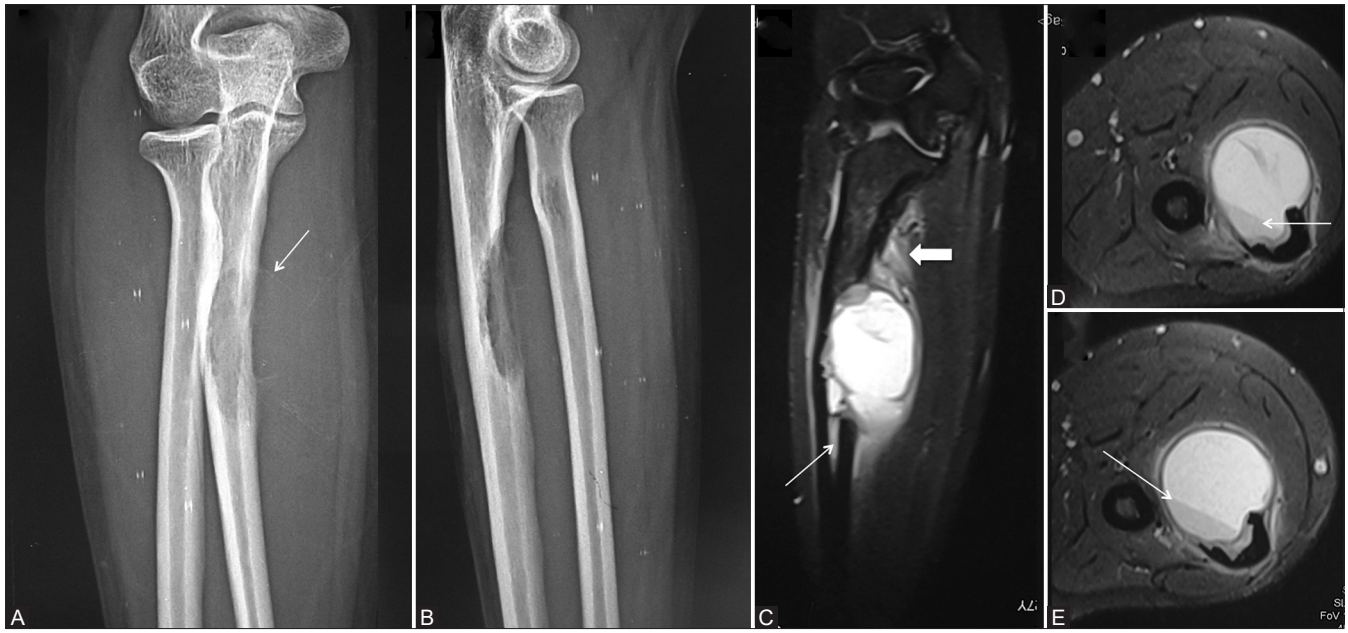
(A-E): A 27-year-old female with painless progressive swelling in the left forearm. (A and B) AP and lateral radiographs of the forearm including elbow joint showing expansile, eccentric lytic lesion with a thin shell of the cortex (arrow) arising from the proximal diaphysis of the ulna. (C-E) Coronal and axial T2W fat-saturated MR images are showing brightly hyperintense lesion having single blood-fluid level (arrow, D and E) associated with bone marrow (arrow, C) and adjacent soft tissue oedema (block arrow, C)
